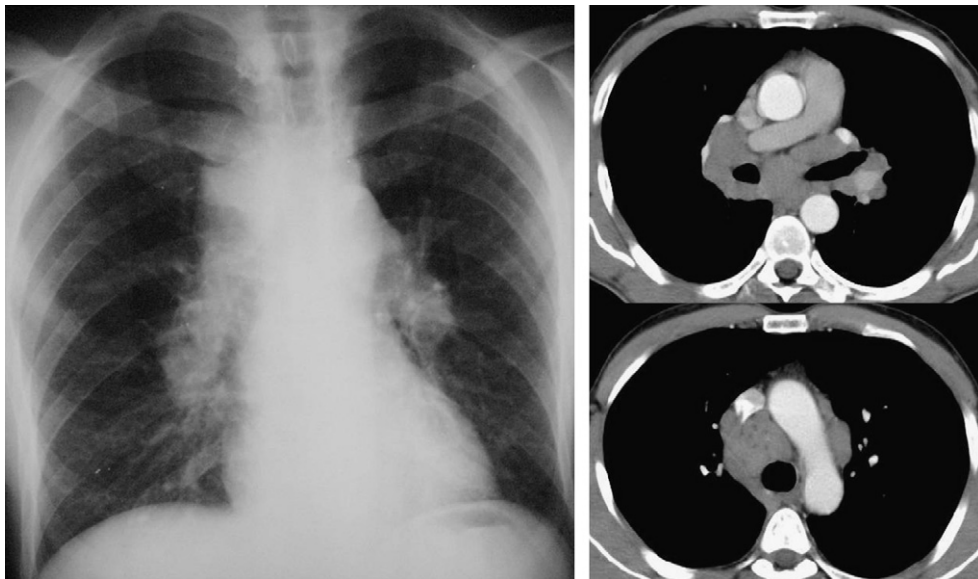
Chest radiography and thorax CT are showing the bilateral hilar and mediastinal multiple lymphadenopathies.
